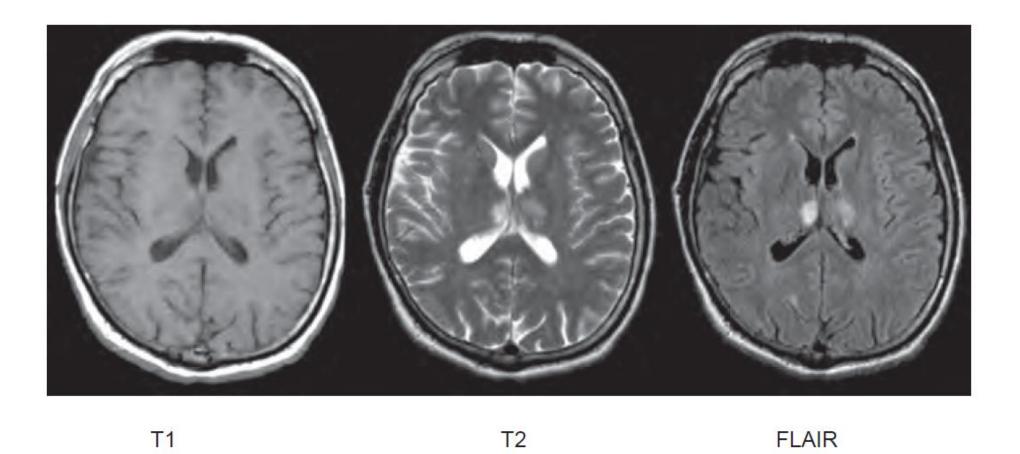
(Left) T1-weighted spin-echo axial brain image (TR = ms, TE = 11 ms); (Middle) T2 weighted spin-echo image (TR = 2,400 ms, TE = 90 ms); (Right) FLAIR image (TR = 10,000 ms, TI = 2,400 ms, TE = 150 ms)..
